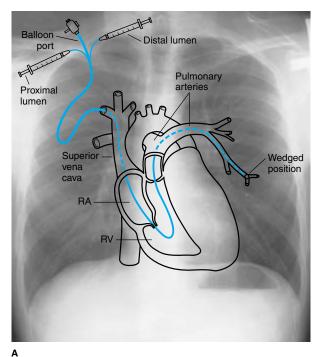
The fluid-filled pulmonary artery catheter is passed into the introducer sheath. (Reprinted, with permission, from: Chesnutt MS, et al [eds]: *Office & Bedside Procedures*. Appleton & Lange, Stamford CT, 1992.)
